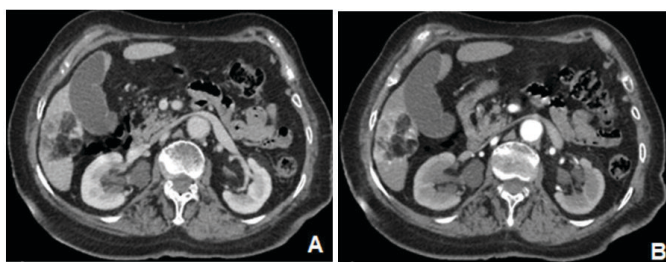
Axial contrast-enhanced abdominal CT. (A) Heterogeneous fatty mass with a homogenization in portal phase. (B) Tissular component with early enhancement in arterial phase.
